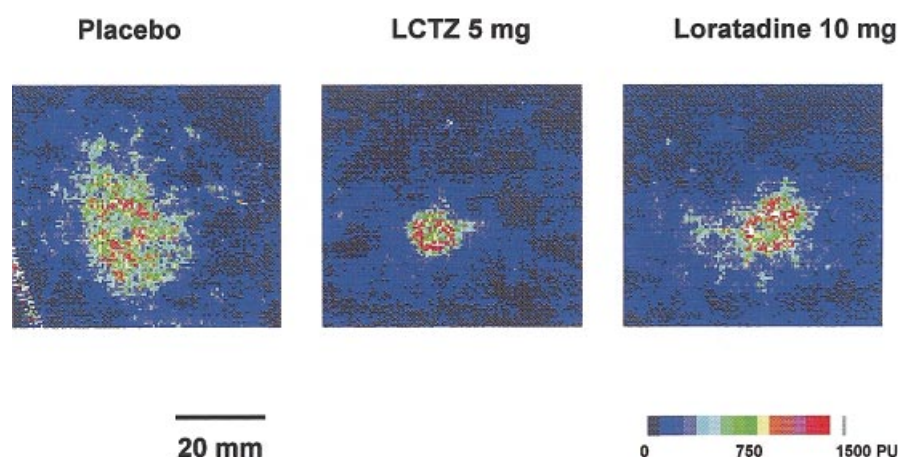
Scanning laser Doppler images taken at 10 min after intradermal injection of 20 µl of 100 µM histamine. The drugs taken orally 4 h before histamine injection were placebo, 5 mg levocetirizine, and 10 mg loratadine. The areas of the flares are 13.2, 3.0, and 9.8 cm², respectively. PU: scanning laser Doppler perfusion units.
